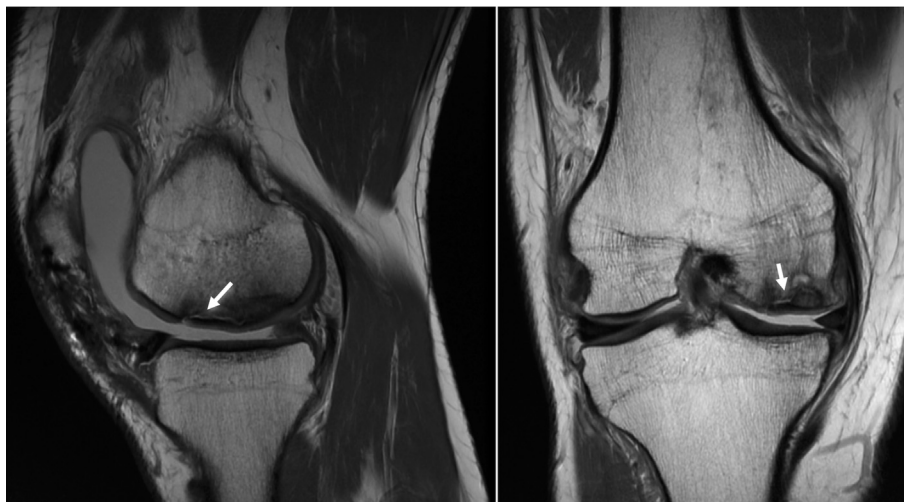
Example sagittal and coronal proton density MRI showing fluid imbibition beneath the subchondral lamina of an osteochondral allograft.
